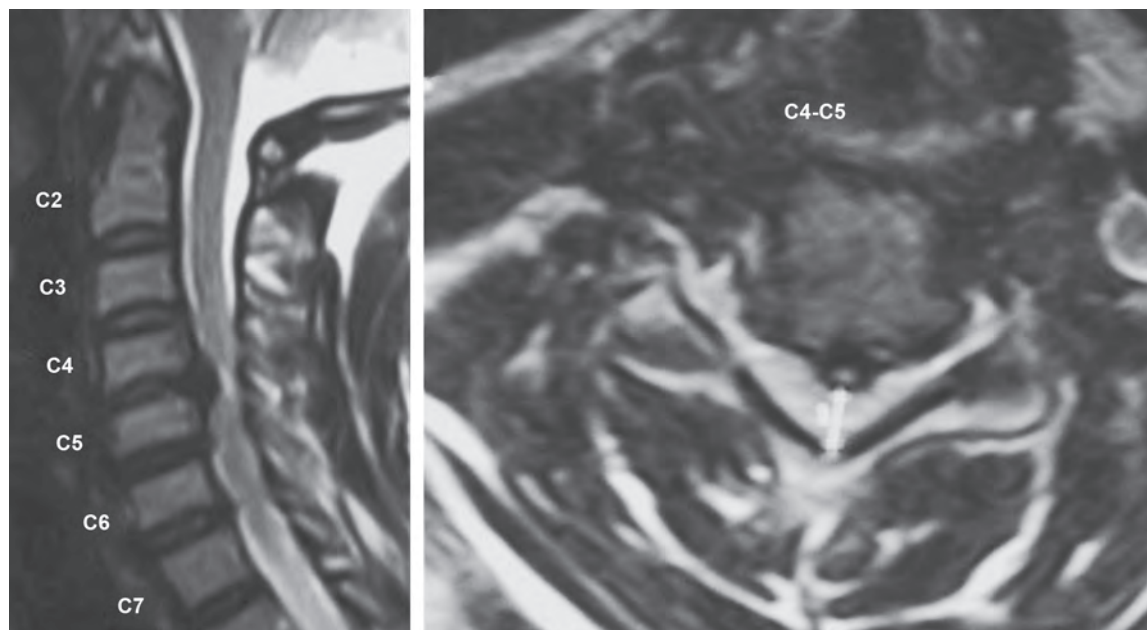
MRI cervical spine of 50-year-old lady showing C4-5 disc prolapse, underwent ACDF
